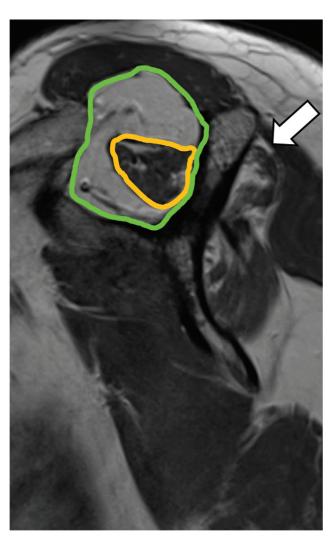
T1-weighted sagittal oblique Y view demonstrating measurement of the occupation ratio, at the intersection of the scapular spine and body. The yellow circle denotes the cross-sectional area of the supraspinatus muscle; the green circle denotes the area of the supraspinatus fossa. The yellow area is divided by the green area to determine the occupation ratio (R < 0.4, severe supraspinatus atrophy). Note mild fatty infiltration of the supraspinatus (Goutallier grade 1). The infraspinatus (arrow) is also atrophic with more pronounced fatty infiltration (Goutallier grade 3).
